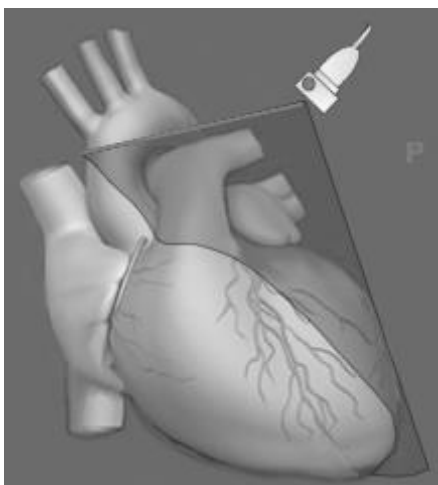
Parasternal long axis.
